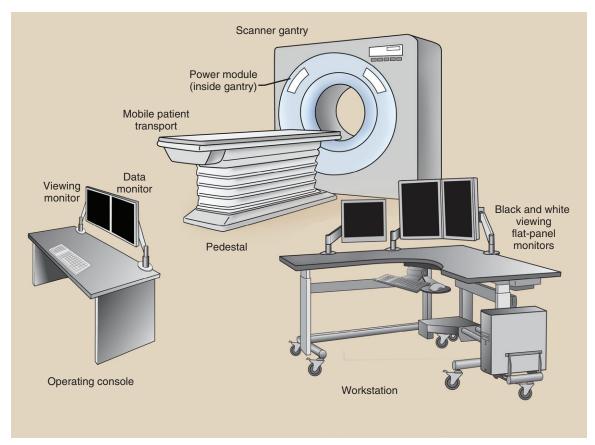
Components of a complete computed tomography imaging system.
